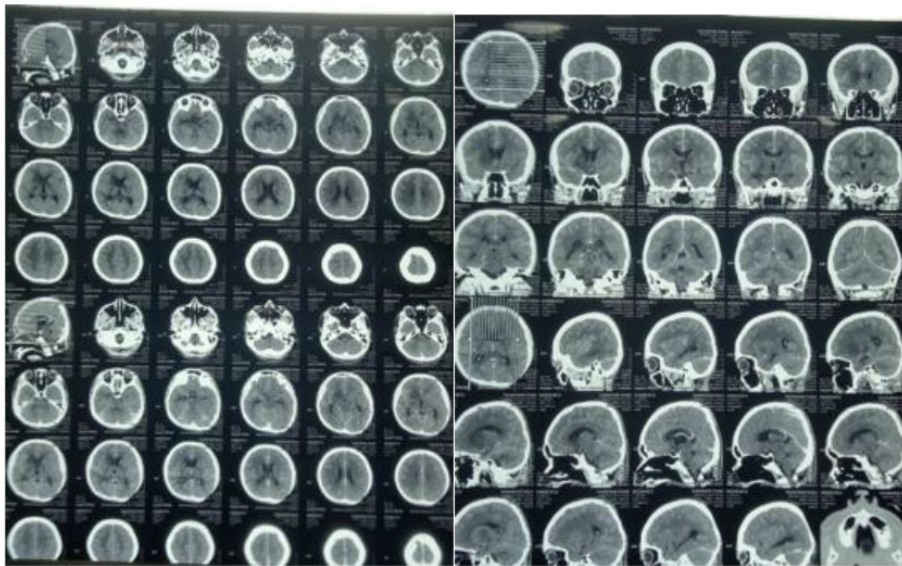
Contrast Head CT showing basal meningeal enhancement (Day 5).
